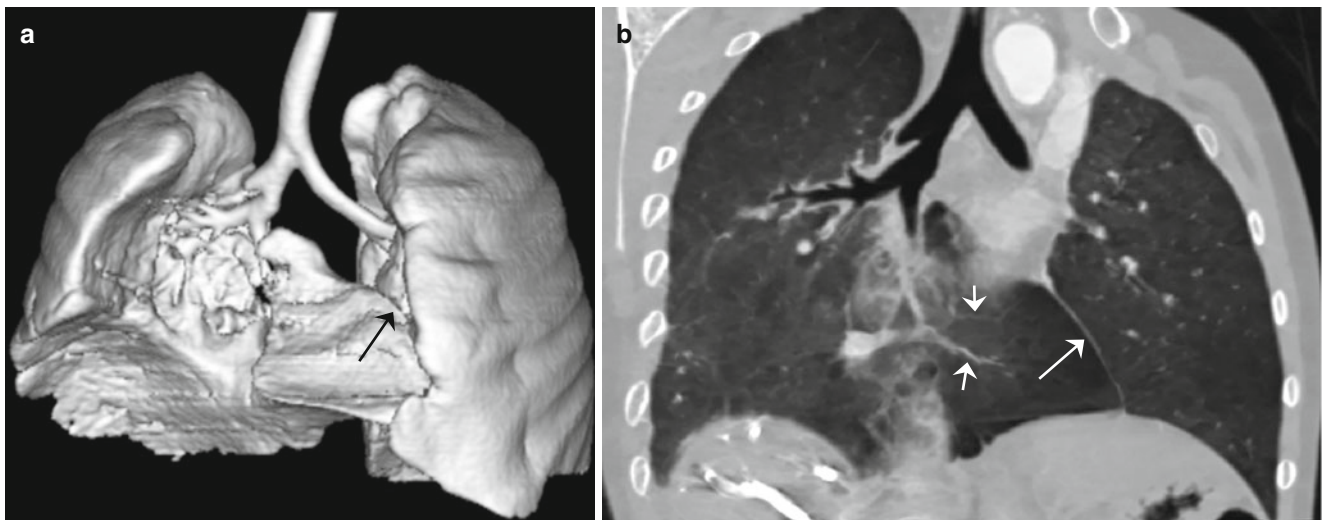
(a, b) Horseshoe lung. Anterior shaded surface display CT image (a) and coronal minimum intensity projection CT image (b) show a fusion of both lungs and a pleural line (*long arrow*) between an
